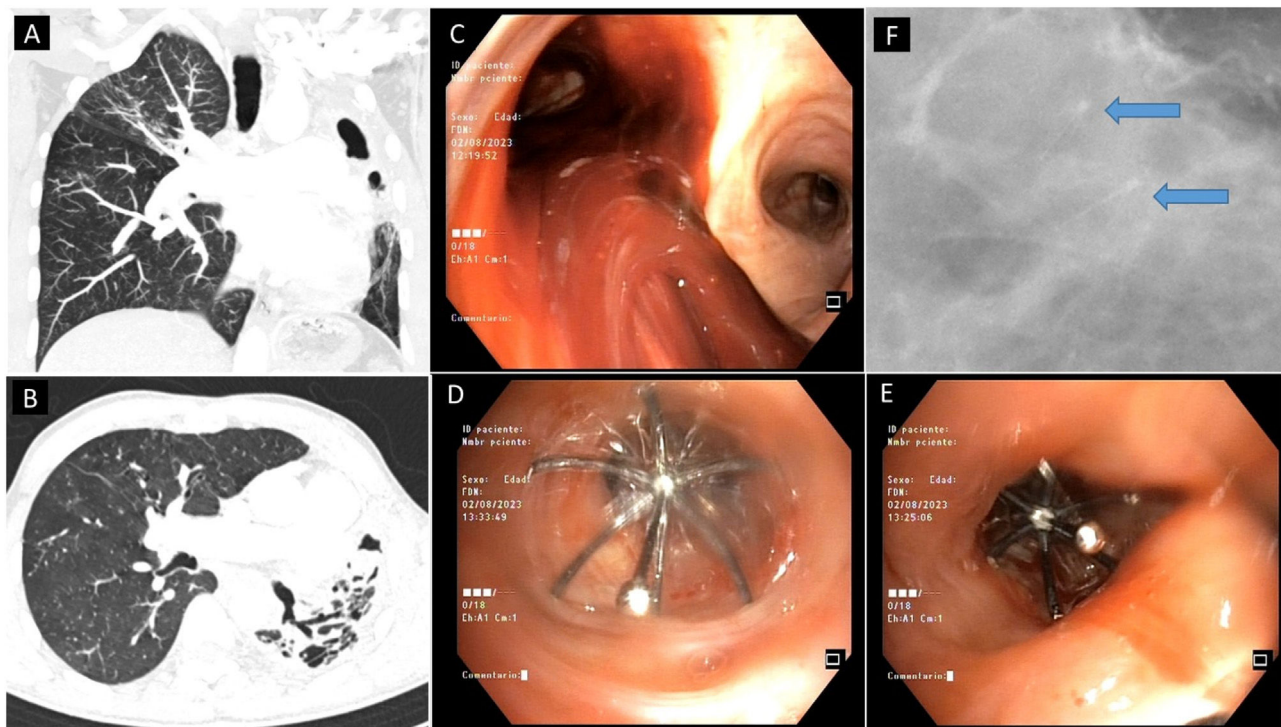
(A and B) CT scan of the coronal and transverse slices, caverns in LUL with loss of volume and structural damage of the left lung. (C) Revision bronchoscopy, clots in left main bronchus from LUL. (D) Spiration EBV number 9 in lingula. (E) Spiration EBV number 6 at the top. (F) Chest X-ray, zoom of the LUL apical region showing the 2 EBVs.
